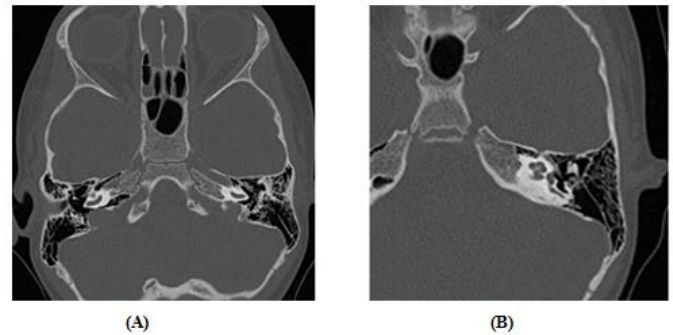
Left External Auditory Canal Atresia with intact middle ear ossicles (A) and (B) Axial HRCT images shows left side atresia of external auditory canal with normal middle ear ossicles
